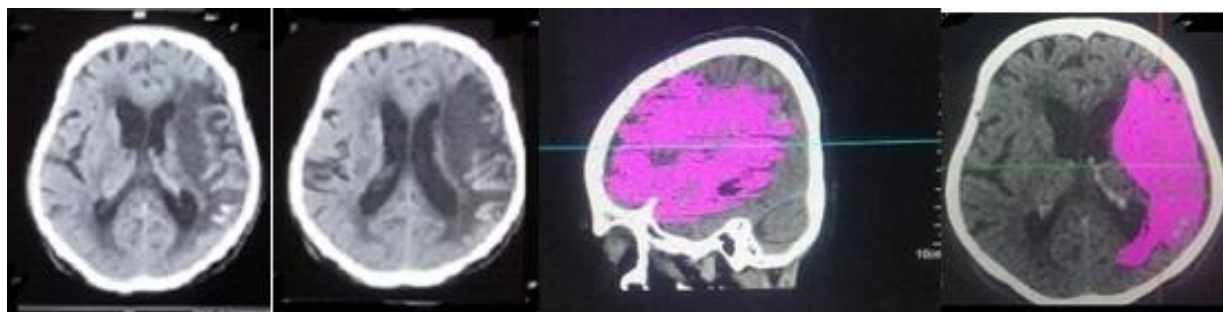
Figure 2. Non contrast CT after one month infarct. The infarct volume was 135 cm^3 . There was cortical ribbon hyperdensity due to proteinaceous material.
